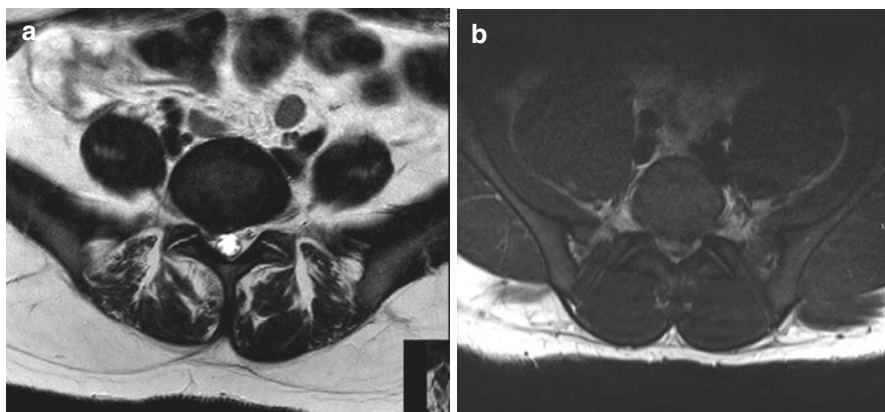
(a) Axial MRI images of a 38 y/o nonathletic patient with a L5-S1 HNP. (b) Axial MRI images of 19 y/o elite athlete (who is currently an elite NFL player) with a L5-S1 HNP. Note the difference in anthropometric factors (cross-sectional area of the psoas, paraspinal muscles, and other anatomic structures) compared to the nonathlete in (a)
